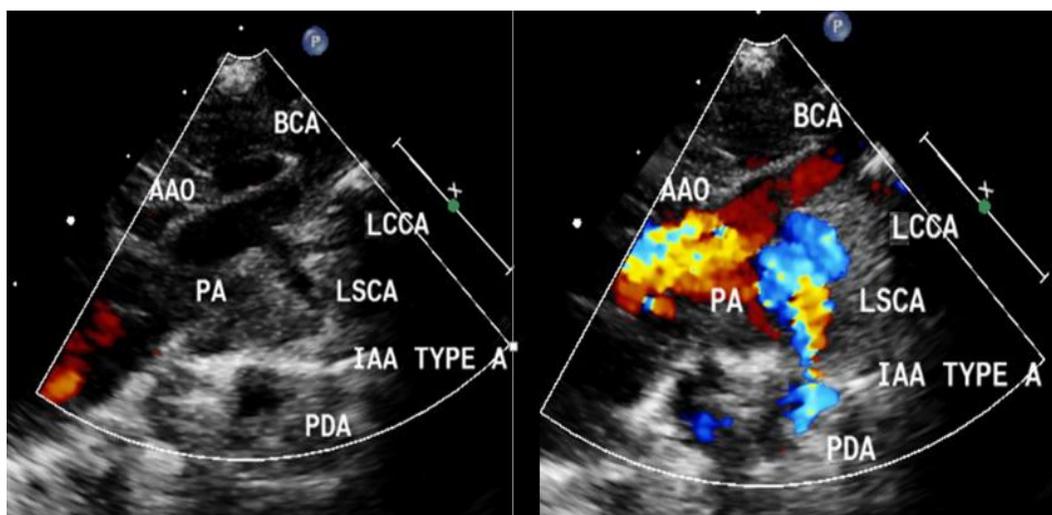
Supra sternal views of transthoracic echo showing good size ascending aorta and brachiocephalic artery, left common carotid artery, left subclavian artery Smallish transverse arch with Interruption of aorta below the left subclavian artery, Small PDA with restrictive right to left flow.(AAO, Ascending aorta: PA, Pulmonary artery, BCA: brachiocephalic artery, LCCA: left common carotid artery, LSCA: left subclavian artery, PDA patent ductus arteriosus, IAA: interruption of aortic arch)
